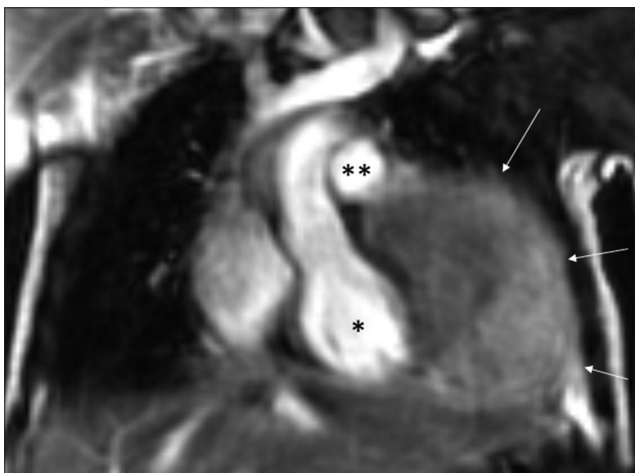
Coronal magnetic resonance imaging, 1.5 T, balanced steady-state gradient echo sequence, large pericardial mass (arrows), no invasion of left ventricle (*), no invasion of pulmonary artery (), and no invasion of chest wall
